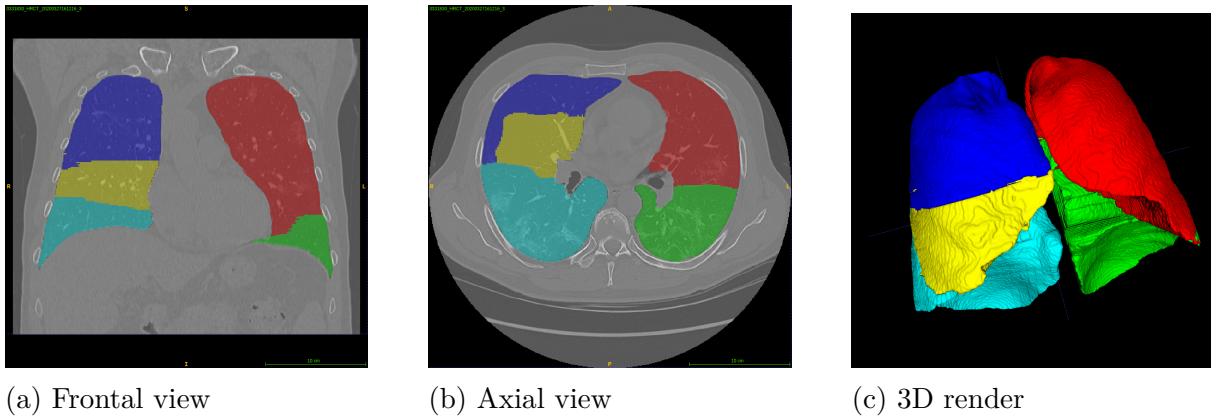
2.2a and 2.2b show the mask as generated using the `lungmask` software overlaid on a chest CT scan. 2.2c shows a 3D render of the lung mask, in a slightly rotated frontal view (note the cardiac notch on the medial aspect of the left lung). The colors represent the different lobes. Note the irregularities at the boundaries caused by uncertainty in the `lungmask` model. Original chest CT from the Italian dataset, images rendered using ITK-SNAP imaging software
